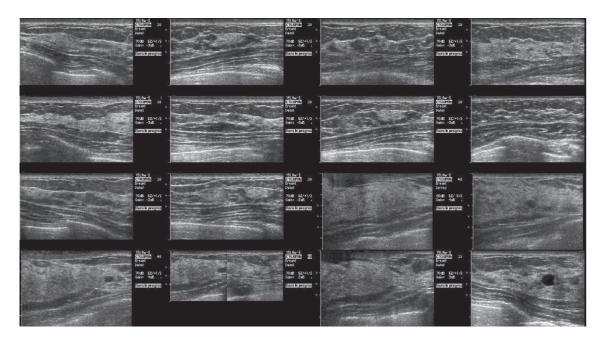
Second look ultrasound showed irregular hypoechoic mass at 6 o'clock position
